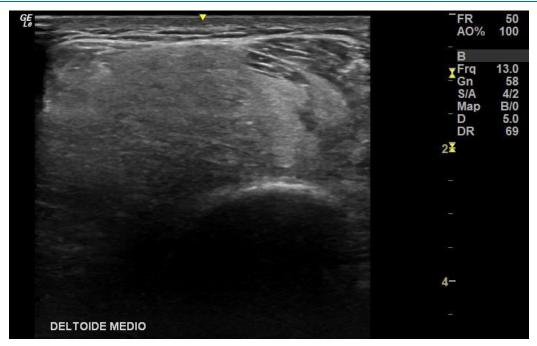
Deltoid muscle showing loss of the usual fibrillar pattern on ultrasound (6-15 mHz linear transducer) and increased diffuse echogenicity due to the presence of intramuscular exogenous filler (pmma).
